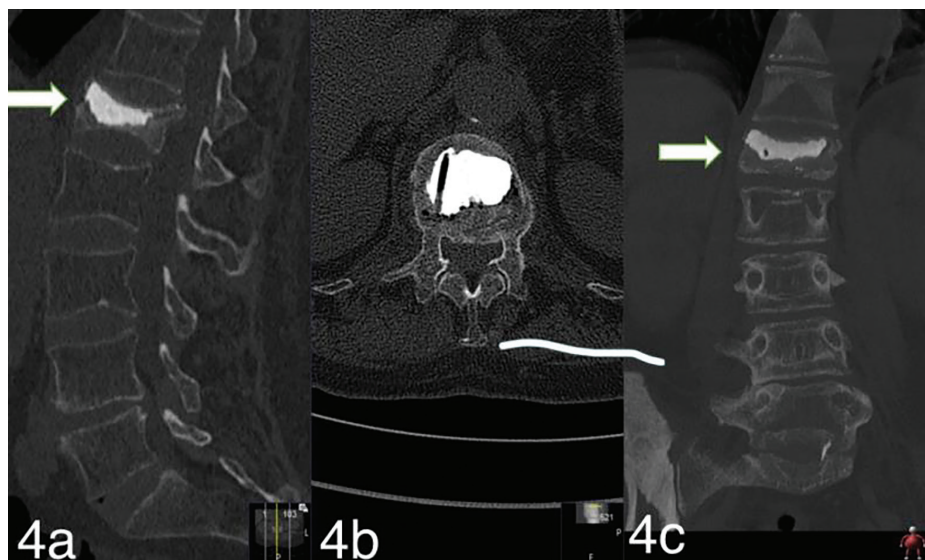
a) Preoperative sagittal computed tomography, b) Preoperative axial CT, c) Preoperative coronal CT.
